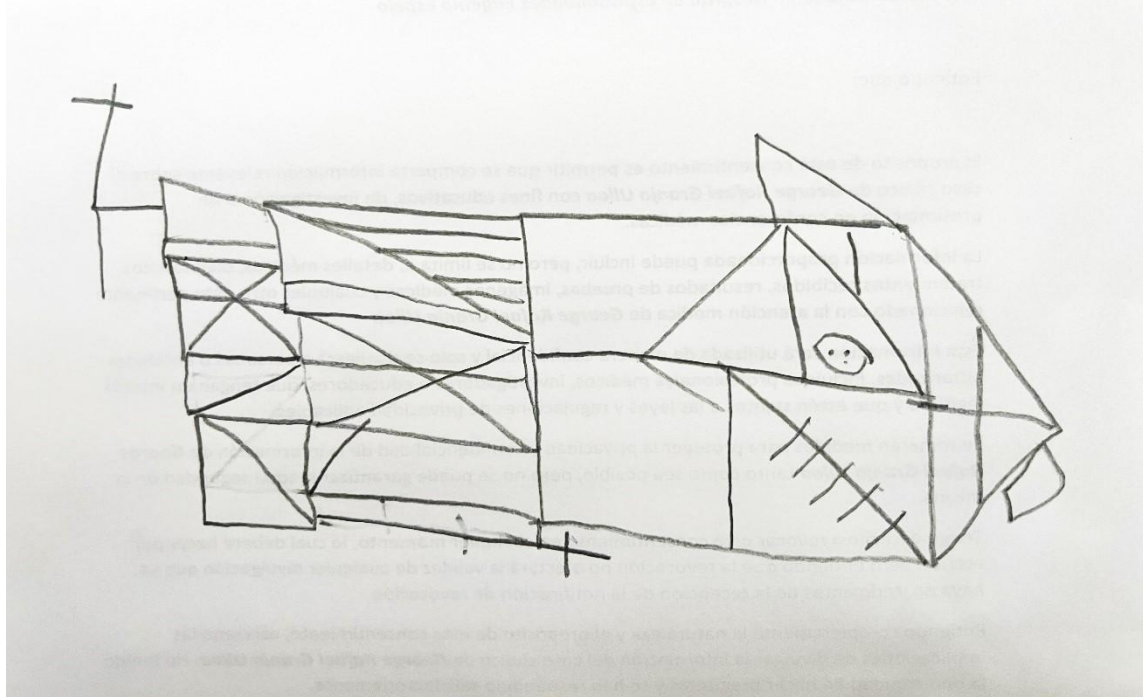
Magnetic resonance image, right frontal gliosis and hydrocephalus are identified by Evans index by 0.31. The patient's performance at this second time point, through the integrated copy of the ROCF (Figure 3), maintains errors typical of his epilepsy, but evidences radical differences in terms of his pre-surgical functioning.
